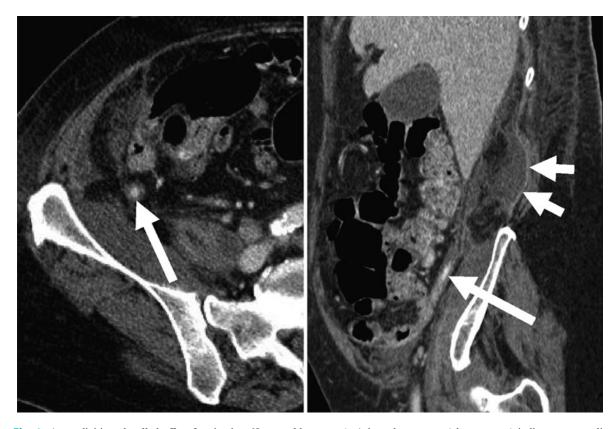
Appendicitis and walled-off perforation in a 69-year-old female, contrast-enhanced CT with reformatted sagittal image (*right panel*). Thickened appendix in retrocecal position with contrast-enhancing wall, periappendiceal fat infiltration, and a calcified appendicolith in the appendiceal base (*long*
